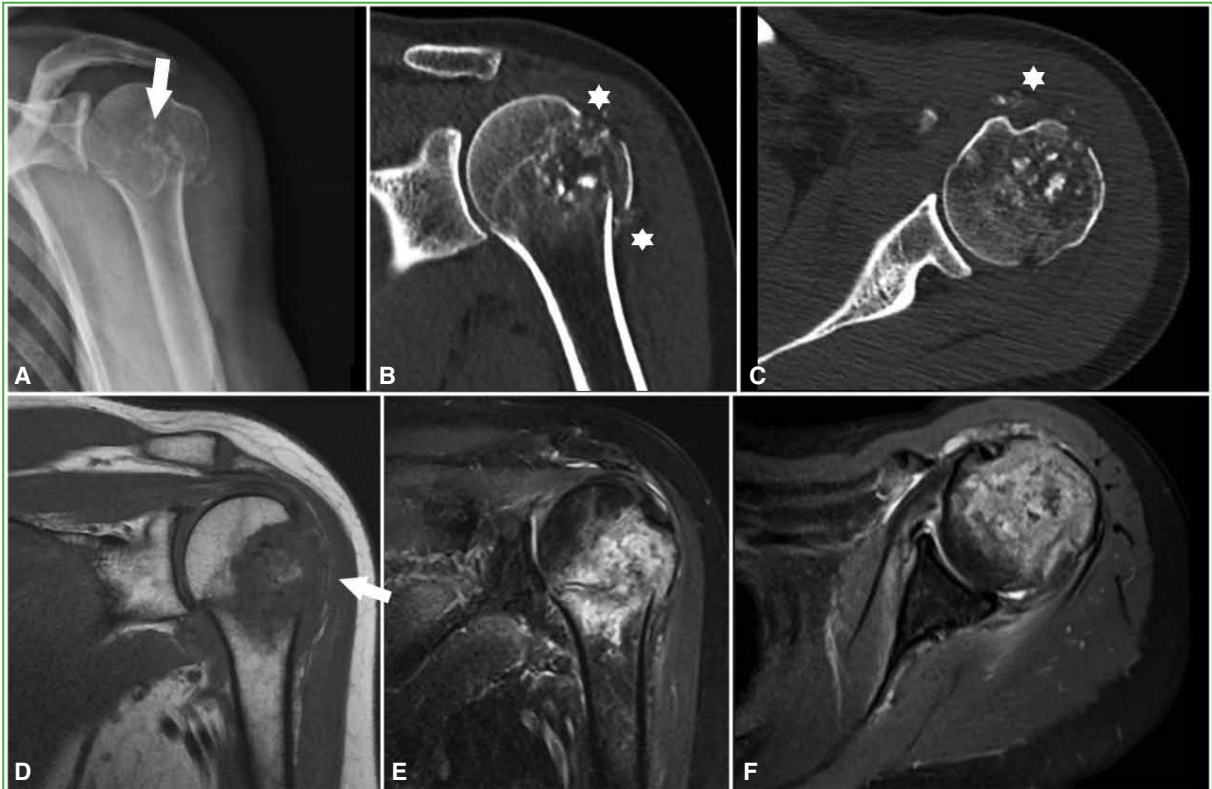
Chondrosarcoma. A. Radiograph of the left shoulder in internal rotation. Lesion that alternates radiolucent and radiodense areas (popcorn) (arrow), associated with cortical rupture due to pathological fracture. B and C. Computed tomography, coronal (B) and axial (C) sections of the humerus. A pathological fracture on pre-existing heterogeneous lesion. Dense images are observed in soft tissue topography (asterisks). D. Magnetic resonance imaging in T1 sequences, coronal plane. A predominantly hypointense lesion, with pathological fracture and soft tissue involvement (arrow). E and F. Magnetic resonance in STIR sequences, coronal and axial planes, respectively. A predominantly hyperintense lesion with significant bone edema.
